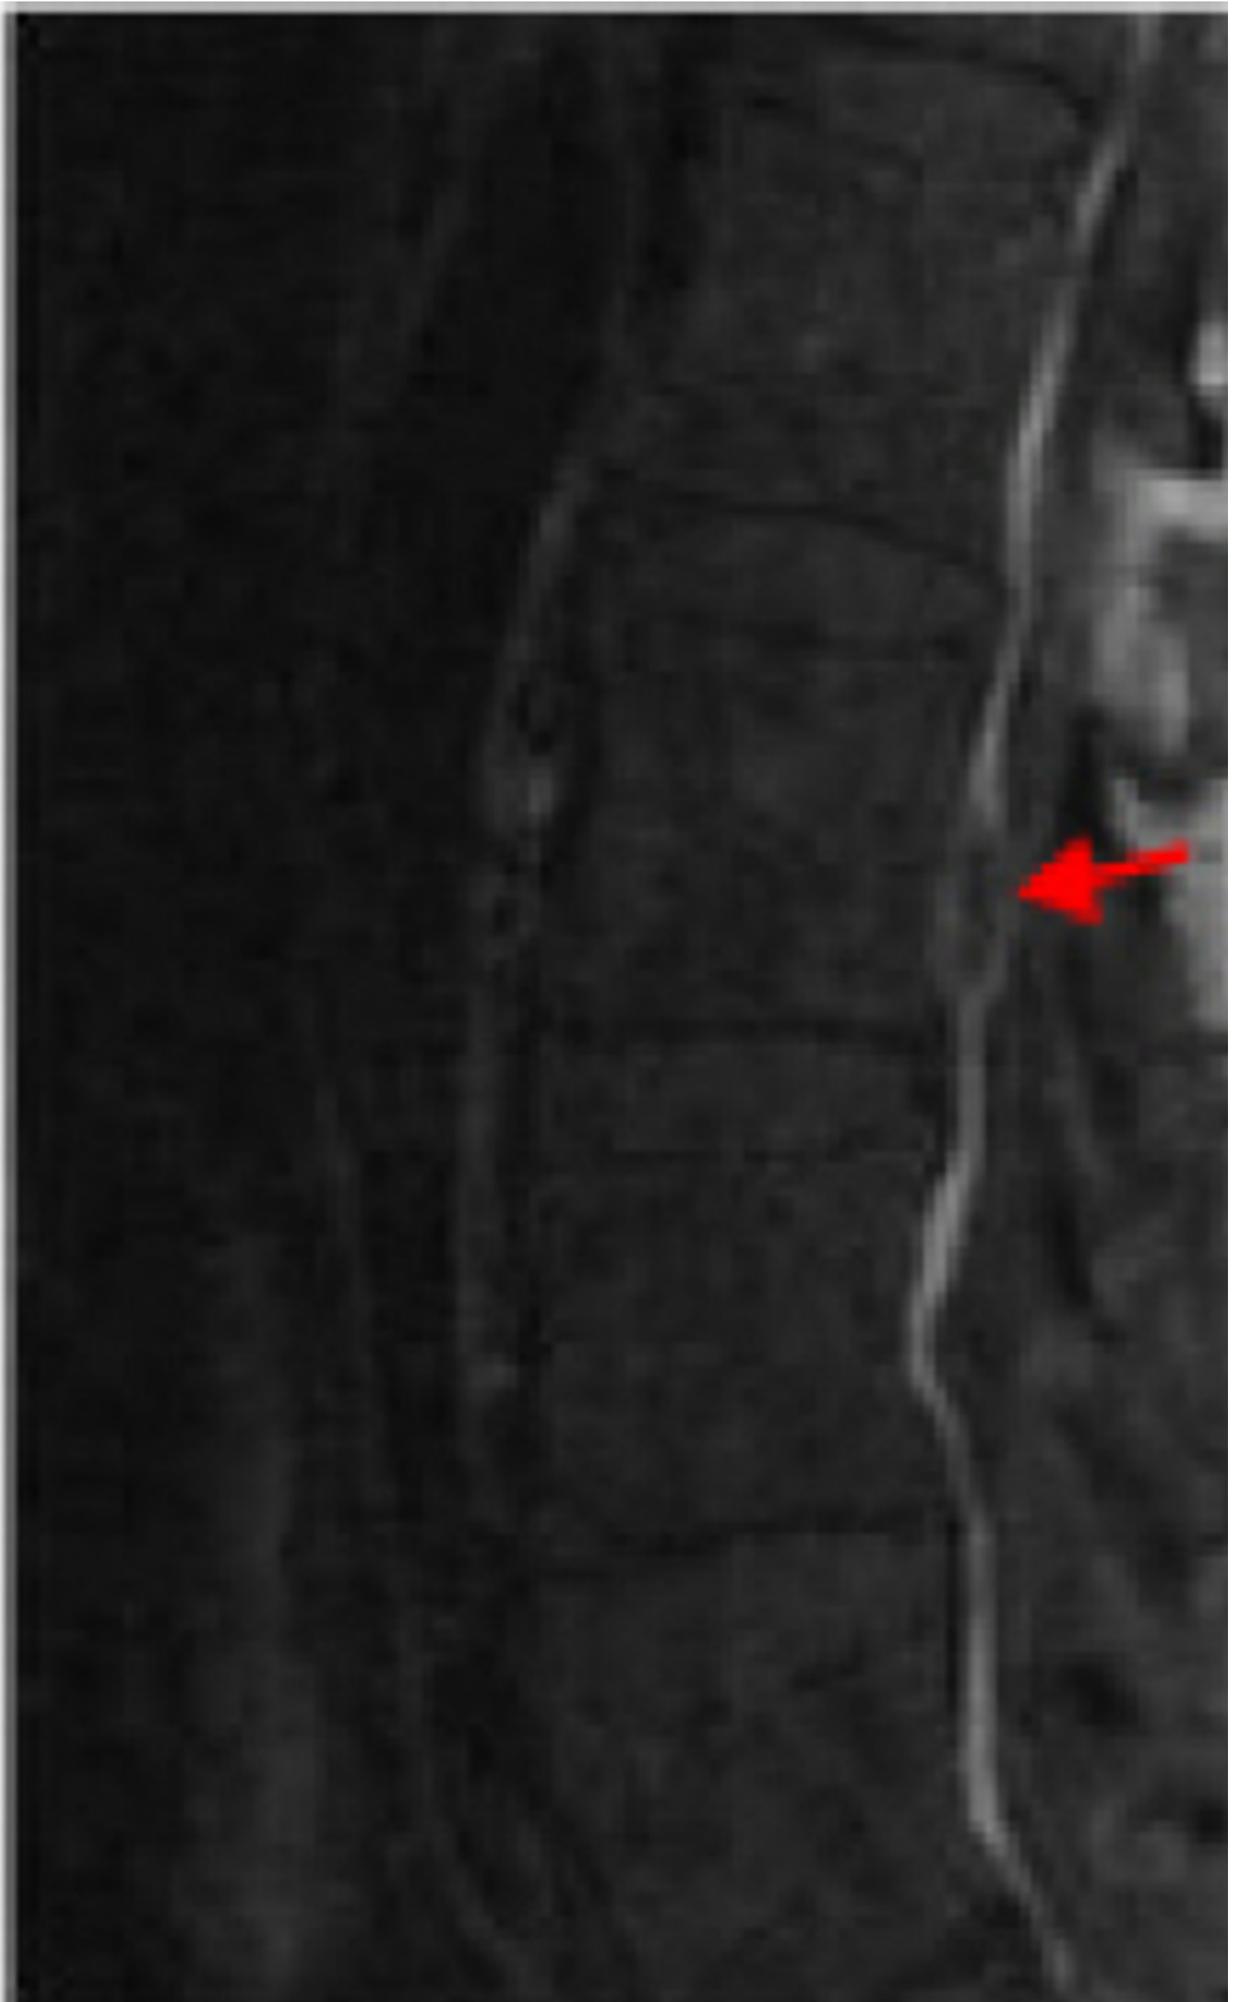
Sagittal T1 Weighted Lumbar Spine MRI image showing Sequestered Disc Fragment
